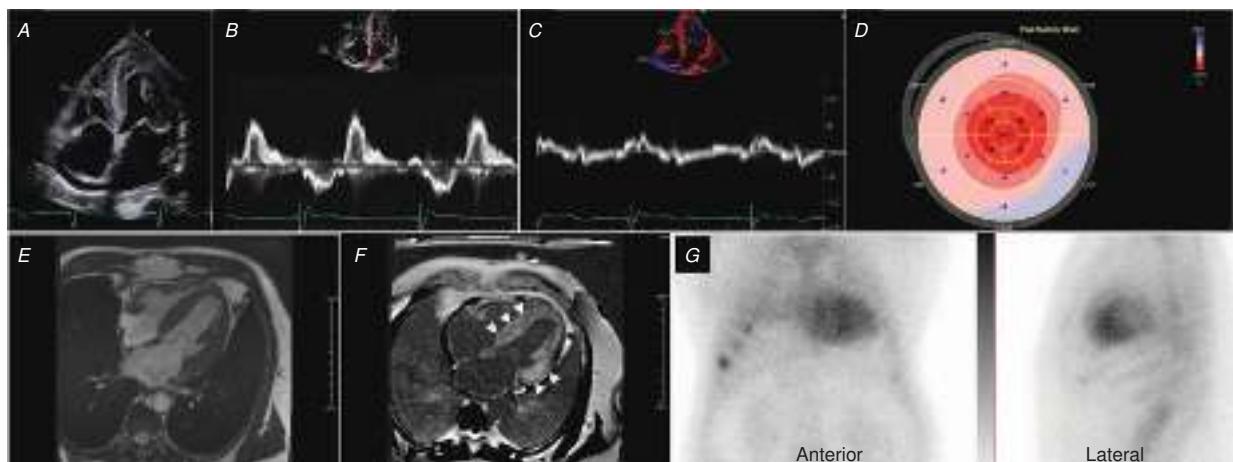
Multimodality cardiac imaging in a 71-year-old man with history of atrial fibrillation, heart failure with preserved ejection fraction, numbness in his fingers, a history of bilateral carpal tunnel surgery, and remote history of back surgery with L3 and S1 fusion. *A*, Two-dimensional echocardiogram demonstrating moderate increase in left ventricular thickness with a visually estimated left ventricular ejection fraction of 45–50% and small pericardial effusion. *B* and *C*, Mitral inflow and tissue Doppler demonstrating abnormal diastolic function (E/e' was >20 , consistent with elevated left ventricular filling pressure). *D*, Bull's-eye strain map demonstrating abnormal global longitudinal strain at the basal segments (pink and blue colors) with characteristic apical sparing (red color). *E*, Cardiac MRI study showing normal left ventricular cavity size, mildly increased left ventricular mass, and mildly enlarged right and left atria. *F*, The MRI shows a large amount of diffuse late gadolinium enhancement of all myocardial left ventricular segments, but it is more prominent in a circumferential subendocardial pattern (arrowheads). *G*, The ^{99m}Tc pyrophosphate images demonstrate increased myocardial uptake of the radiotracer (uptake in the heart is greater than ribs, grade 3). (Images courtesy of Dr. Sarah Cuddy, Brigham and Women's Hospital.)
